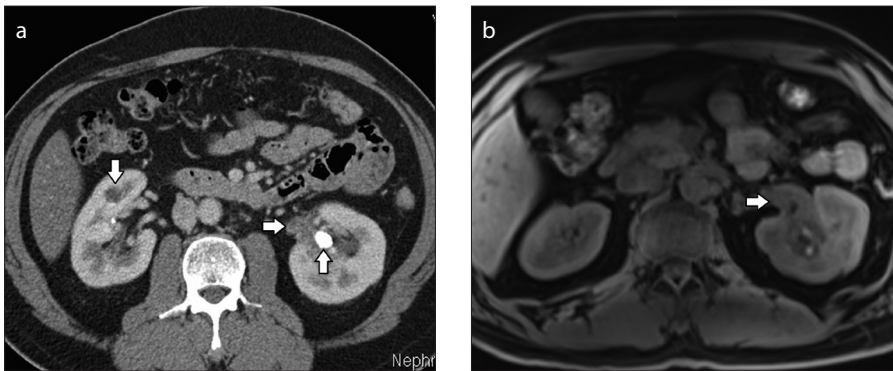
a, b. Axial CT (a) in a patient with autoimmune pancreatitis shows mass-like thickening of the walls of the left renal pelvis and the proximal ureter (*right arrow*); a renal stone is also seen (*up arrow*). Pathogenesis could be IgG4-related or due to inflammation secondary to renal stone. Also note a hypodense nodule in the right kidney (*down arrow*). T1-weighted image (b) of the same patient at a higher level, during a 2-month follow-up shows persistent thickening of the left renal pelvis wall (*right arrow*). The nodule in the right kidney has resolved.
